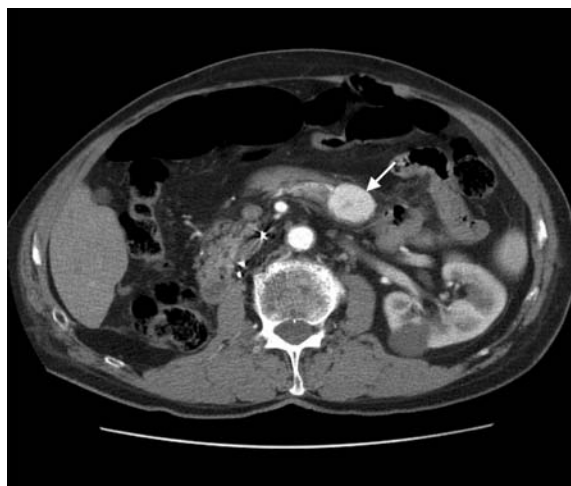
Computed tomogram showing hyperattenuating lesion in the body of the pancreas (arrow). Primary pancreatic adenocarcinoma is usually hypoattenuating. This lesion would also be consistent with an islet cell tumor. The right kidney is absent. This lesion is a metastatic renal cell carcinoma.
